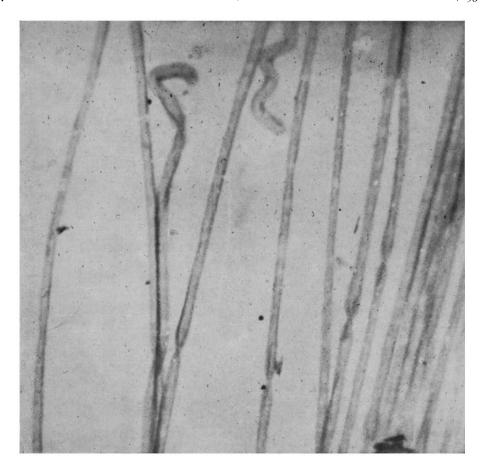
Single nerve fibres from the sciatic nerve in frog. Magnification 200 \times . 4000 volts x-rays, filtered through 9 μ Al. The *black* areas are those more opaque to x-rays.
